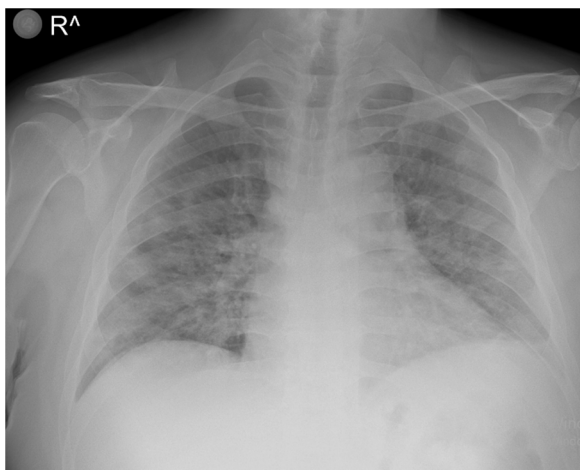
Chest radiography showing reticulonodular density in all bilateral zones.
